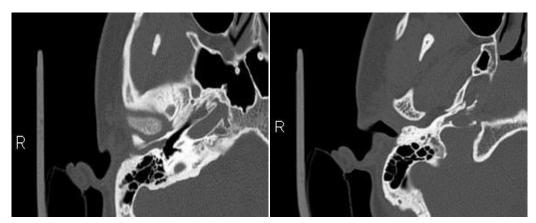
CT axial & coronal images of 16 year old girl shows soft tissue density lesion along entire length of bony canal sparing the cartilaginous external meatus on right side.
